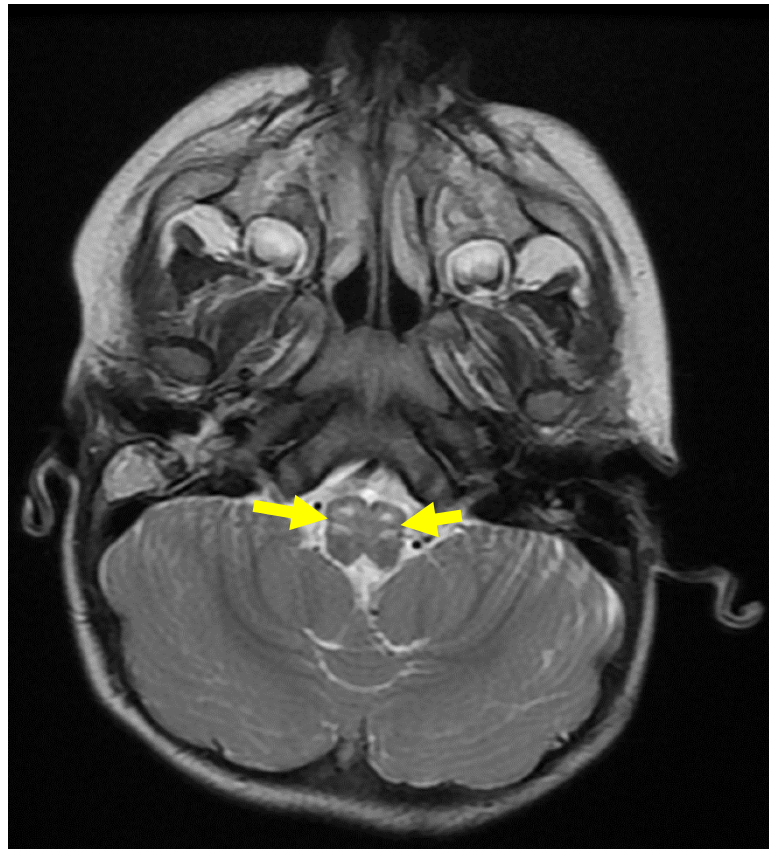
Brain MRI neuroradiological image for Patient 4-III.
